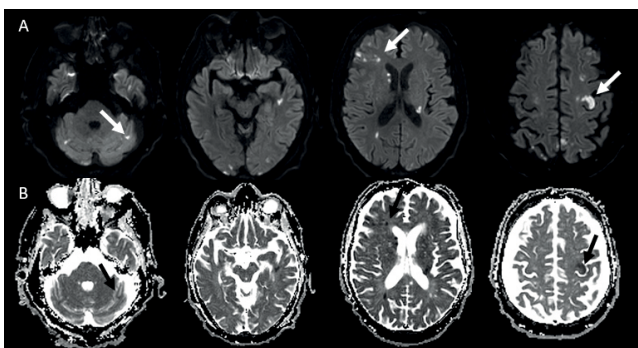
Brain MRI diffusion-weighted image — DWI (Row A) showing multiple high signal intensity lesions in the cerebral and cerebellar hemispheres involving three different vascular territories (Three Territory Sign), with apparent diffusion coefficient — ADC (Row B), showing the same lesions with low signal intensity.
